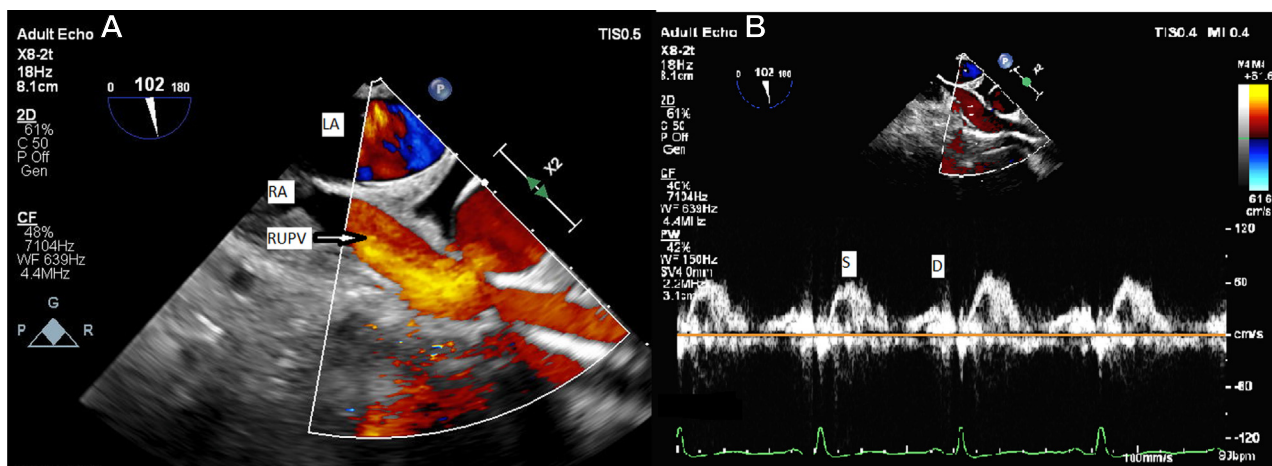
Rightward rotated two-dimensional TEE, midesophageal long-axis (102°) view with (A) color flow Doppler and (B) pulsed-wave Doppler, demonstrates the anomalous right upper PV draining into the right atrium (RA). LA, Left atrium; RUPV, right upper PV.
